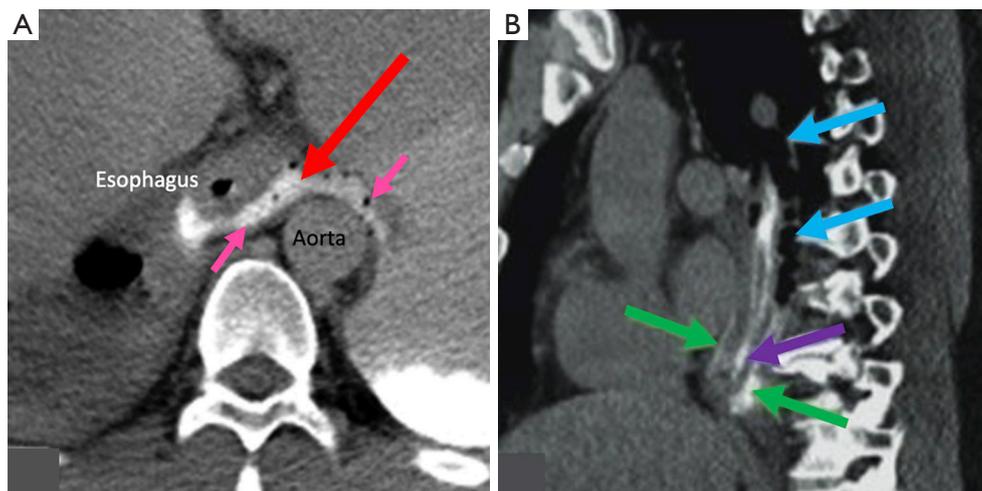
A 54-year-old male patient with distal esophageal perforation. (A) CT axial chest shows oral contrast and air (pink arrows) due to esophageal perforation passing through the AE ligament (red arrow). (B) CT sagittal chest image shows contrast material (green arrows) and air (blue arrows) in the periesophageal space and esophageal lumen (purple arrow). AE, aorto-esophageal; CT, computed tomography.
